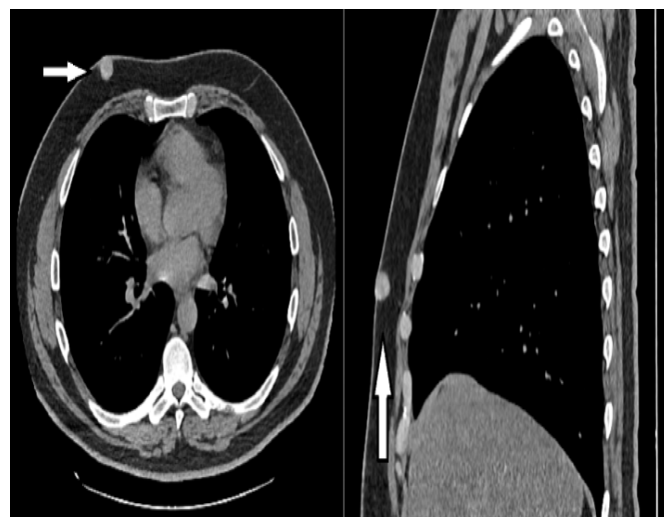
Pre-procedure thorax computed tomography imaging
